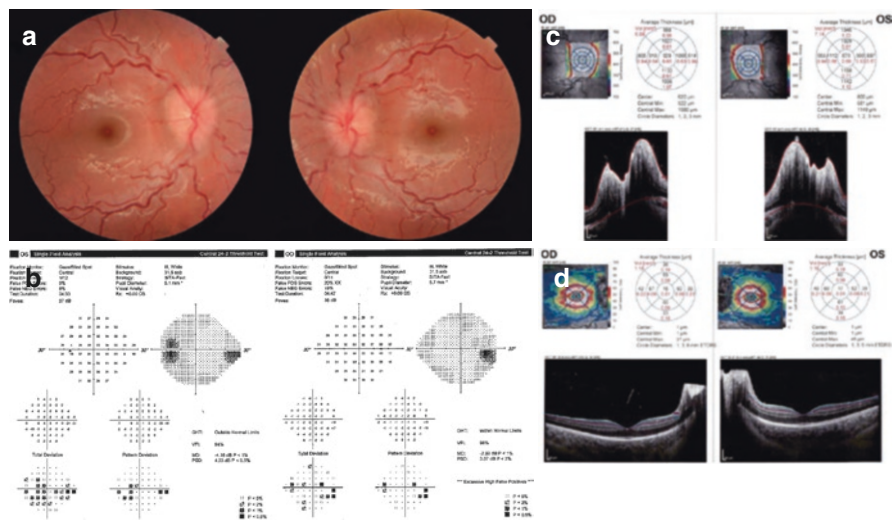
A representative case of a thin, Caucasian 10-year-old girl who presented to the Emergency Department due to worsening headaches. She started to develop headaches, neck pain, and diplopia that progressively worsened over a 3-week period. She had an MRI brain without contrast and MRV that was notable for a partially empty sella, protrusion of the optic nerve heads into the globes, and focal narrowing of the dominant right transverse venous sinus. She had a lumbar puncture performed and her opening pressure was 25 cm H₂O with bland constituents. She was started on acetazolamide in the setting of a borderline opening pressure with other clear signs of increased intracranial pressure. Given the history of headaches, neck pain, and diplopia in the setting of her nontoxic appearance and the fact that she did not fit the typical body habitus for IIH, it was thought that she likely had viral meningitis leading to increased intracranial pressure. On her initial exam, she had normal afferent visual function and bilateral Frisén grade 3 papilledema. (a) Her automated perimetry demonstrated an enlarged blind spot bilaterally. (b) There is poor reliability of the right eye due to high false positives and this probably served to blunt the presentation of the enlarged blind spot in that eye. The left eye also has a hint of an early nasal step. The optic nerve head volume demonstrates marked elevation in both eyes. (c) The ganglion cell layer for both eyes shows no evidence of atrophy in either eye. (d) She was started on acetazolamide and had profuse vomiting after each dose. She was transitioned to topiramate and gradually increased to a goal dose of 50 mg twice daily which is approximately 1.5 mg/kg/day). Three months later fundus photography demonstrates resolution of papilledema. (e) Her visual fields had normalized with only a hint of an enlarged blind spot in the left eye (f). OCT RNFL (g) was now performed given the resolution of the edema and her OCT ganglion cell layer (h) remained within normal limits though slightly lower than it had been on presentation
